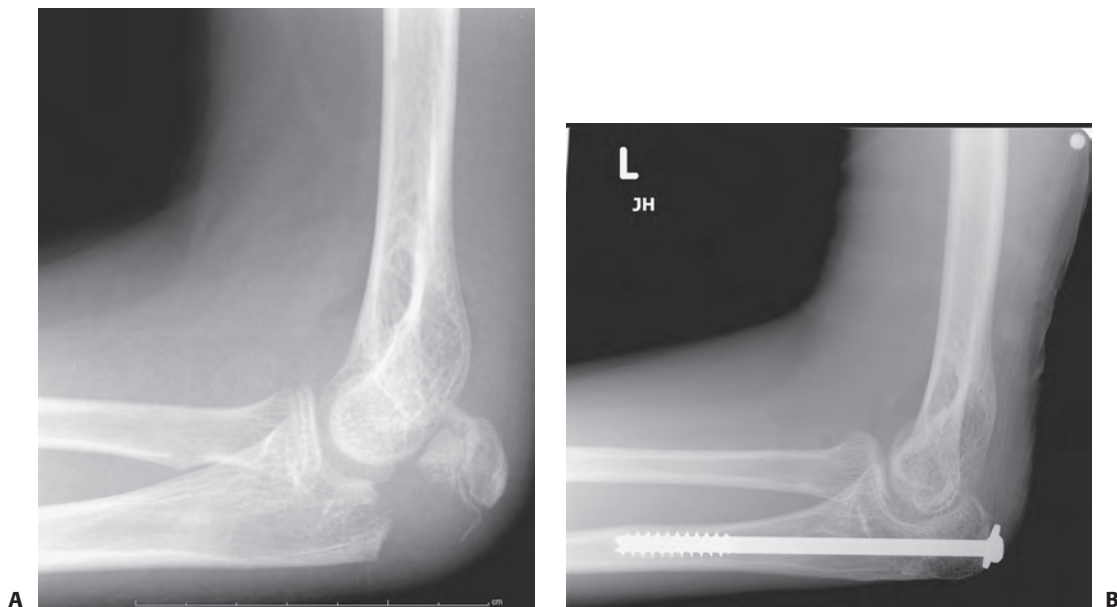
A 13-year-old boy with mild osteogenesis imperfecta presented after a fall on an outstretched arm, with inability to move his elbow, pain, and swelling. Radiographs showed a displaced olecranon fracture (A). This fracture pattern is commonly seen in children with osteogenesis imperfecta and is quite uncommon in healthy children. The patient underwent open reduction and internal fixation. The fracture healed after 6 weeks (B). (Figures reproduced with permission from The Children's Orthopaedic Center, Los Angeles, CA.)
